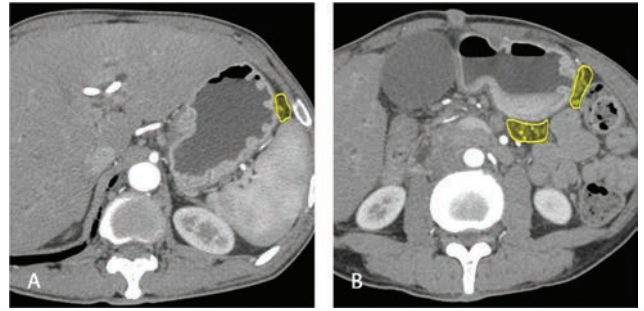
Station 4. Axial computed tomography images in arterial phase depict short gastric arteries (yellow area in A), left and right gastroepiploic arteries along the greater curvature of stomach (yellow area in B) which is the location for station 4 gastric nodes.
